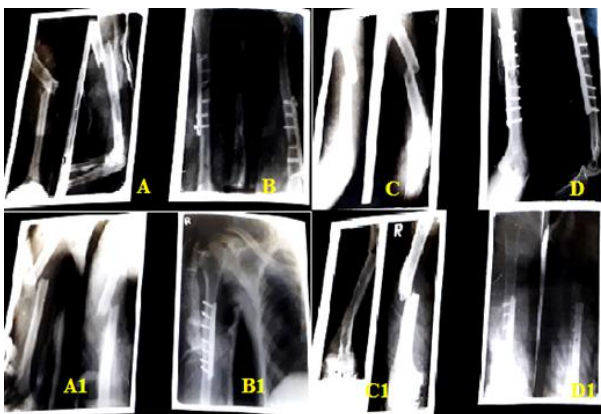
Radiographs: A, A1, C, C1- pre-operative, B, B1, D, D1- post-operative
